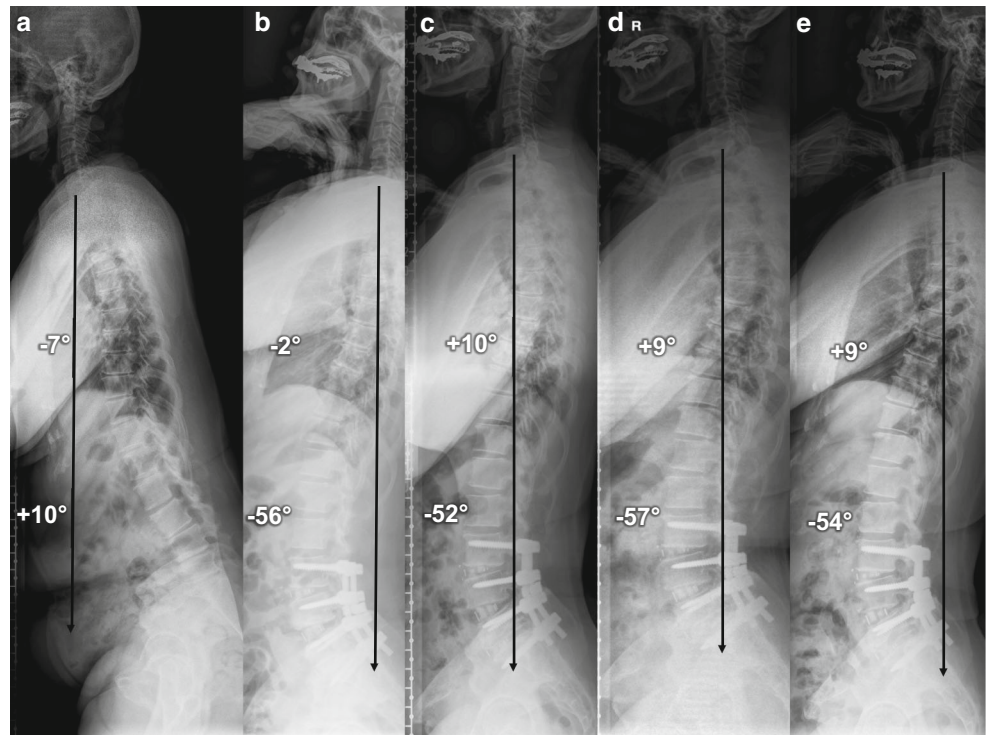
Preoperative (a), postoperative (b), 1-year postoperative (c), 2-year postoperative (d), and 3-year postoperative (e), standing pelvis lateral radiographs. Note the substantial pelvic incidence (PI) increments. Preoperative PI was 48°. Predictive lumbar lordosis (LL) following this PI was 52°. Postoperative LL was corrected to -56° , resulting in overcorrection, and creating negative sagittal
